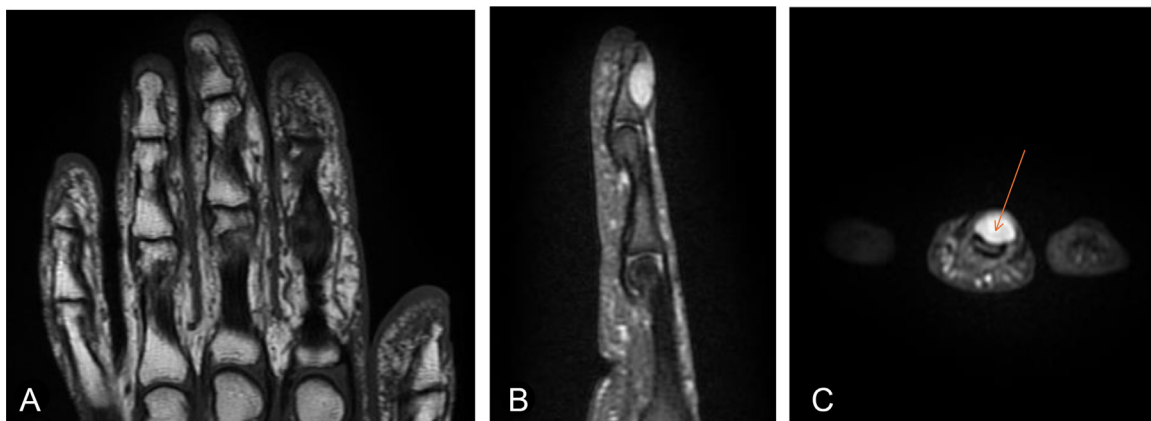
MRI appearance of the tumor: The mass has low signal intensity on T1 (A) and marked hyperintensity on T2 (B). The characteristic “central dot sign,” is visible on the STIR sequence (C, orange arrow).
